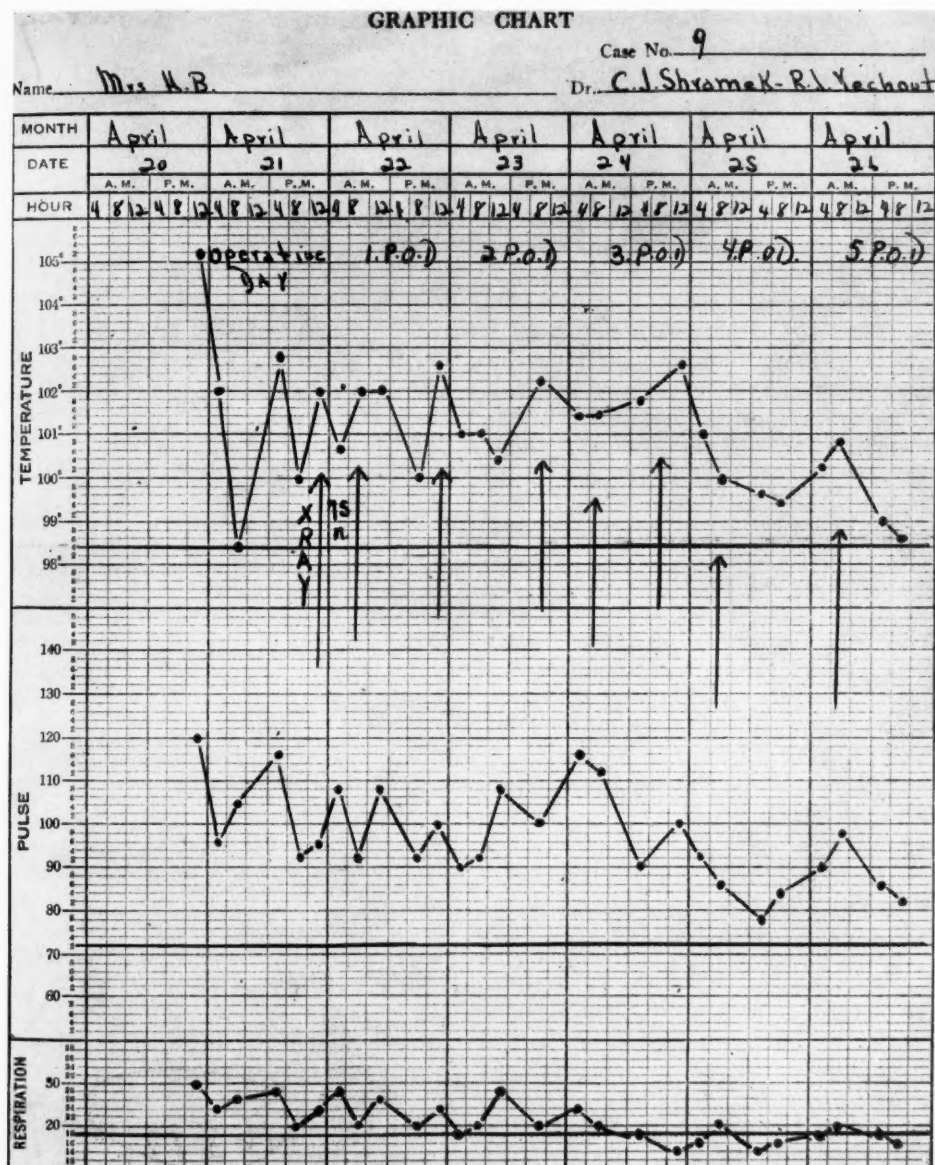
Case 9. Diagnosis: gas gangrene complicating fractured mandible. X-ray technic: kv. 110; ma. 5; distance 40 cm.; filter 1 mm. Al; r units, 75 per treatment, 675 total; port, left side face and neck; result, excellent.
